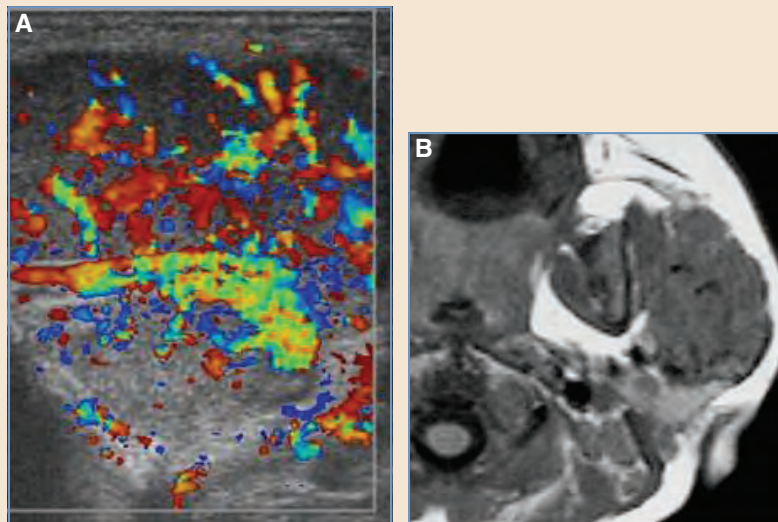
A, Doppler sonogram of an infantile hemangioma in the proliferative phase showing vascular proliferation. B, MRI of infantile hemangioma in the proliferative phase showing vascular filling voids.
